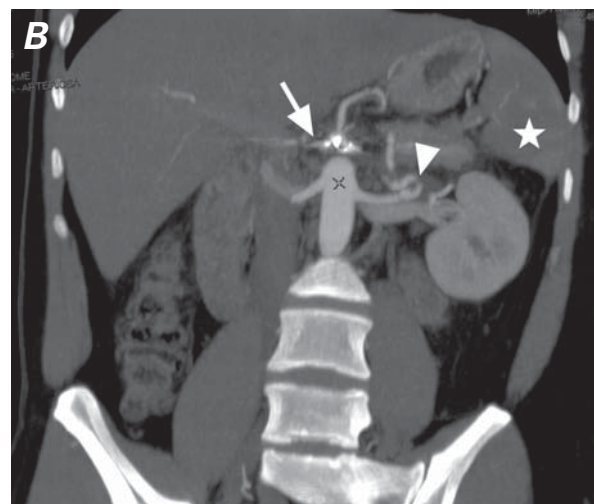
Computed tomography shows A) complete exclusion of the aneurysm with a patent spleno-hepatic stent-graft (arrow) and normal appearance of the hepatic artery (arrowhead); B) reno-splenic bypass patency (arrowhead), exclusion of the celiac trunk aneurysm (arrow), and a normal spleen without infarct (star).
